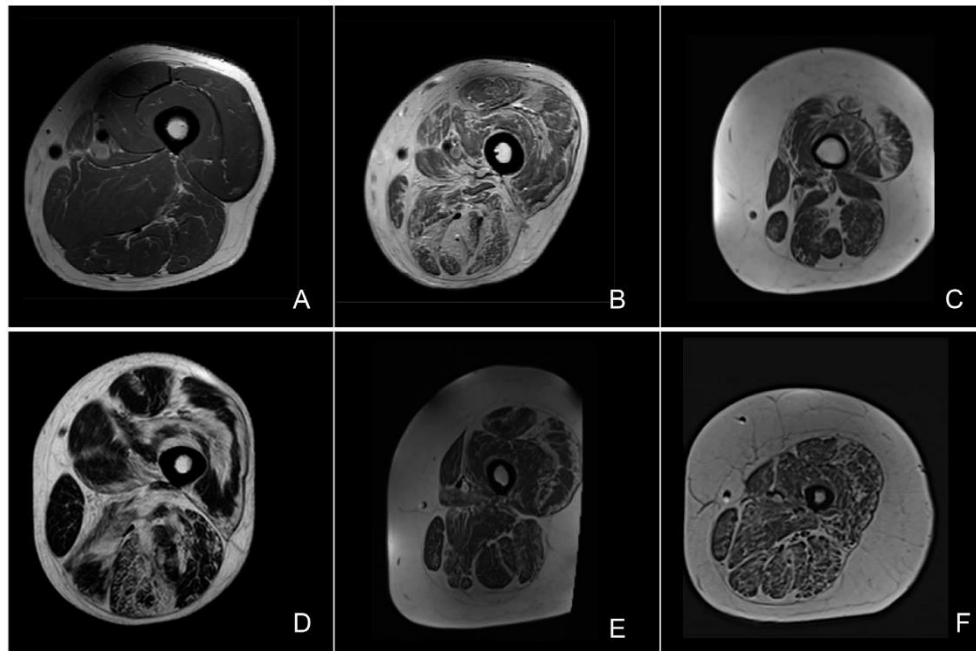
Muscle MRI of the patients with c.7447A>G mutation.
